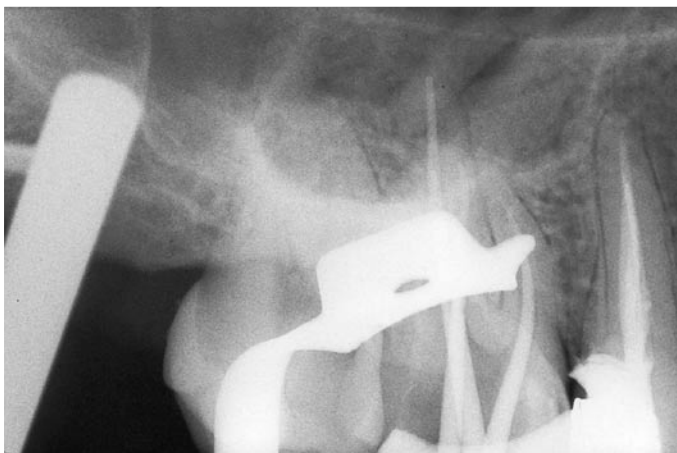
The cylindrical shadow to the left is caused by the metal frame in the path of the X-rays.
